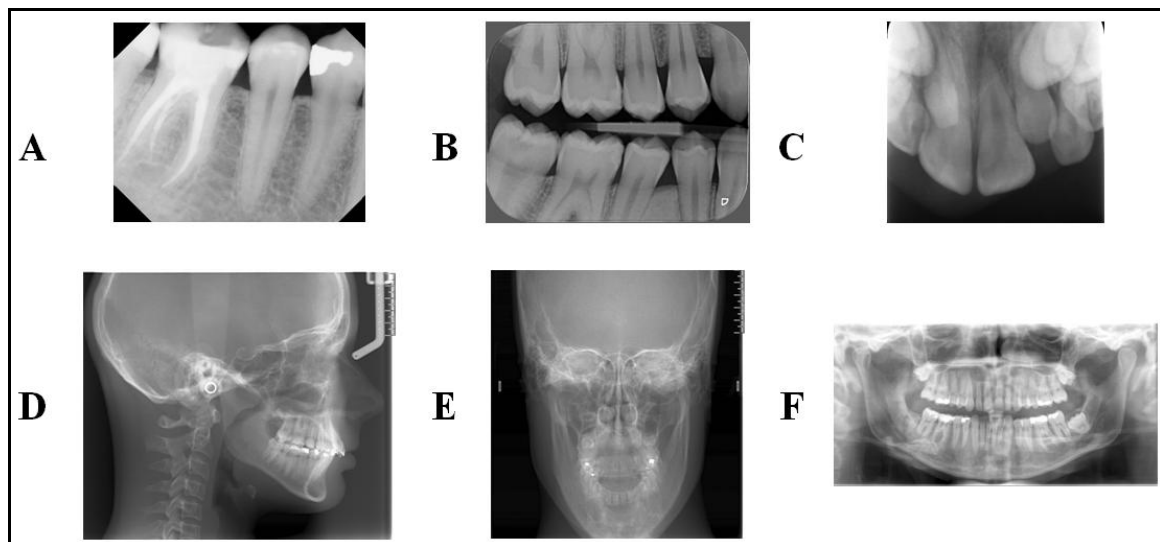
Intra- and extra-oral radiographic and (non-computed) tomographic techniques. (A) periapical intra-oral radiograph (IOR), (B) bitewing IOR, (C) occlusal IOR, (D) lateral cephalogram, (E) anteroposterior cephalogram, (F) panoramic radiograph.
